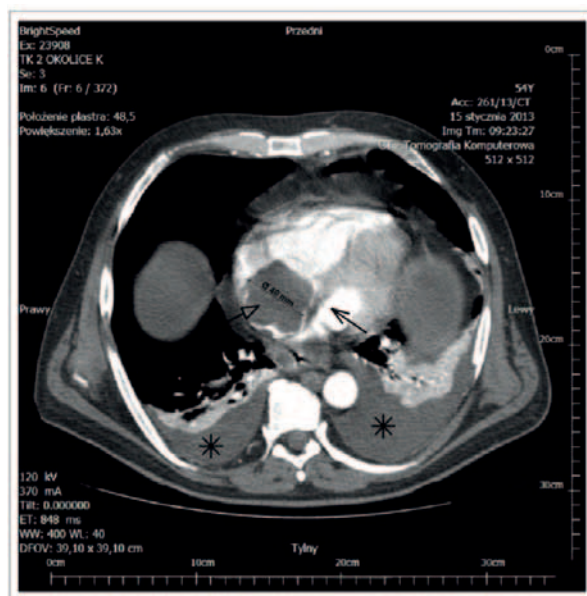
CT scan done during second hospitalization. The image of heart revealed masses in right atrium (marked by $\rightarrow$), extended from inferior vena cava. Left atrium is marked by $\rightarrow$. In addition the free fluid in both pleural cavities is presented (*).
